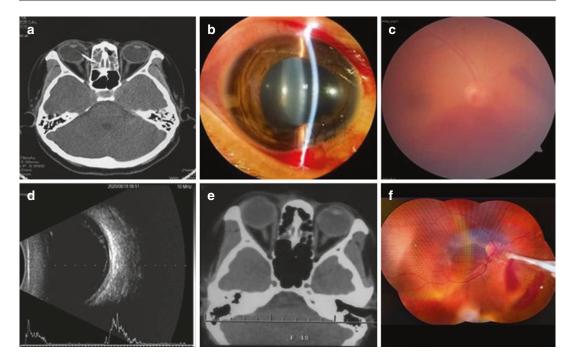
(a) A 26-year-old woman was injured by an iron foreign body in her right eye for 8 hours on right eye with the vision of no light perception. And the iron foreign body penetrated the eye from cornea to orbit confirmed by CT. (b) Slitlamp examination revealed an 6 mm full-thickness irregular corneal laceration from 4:00 directly
